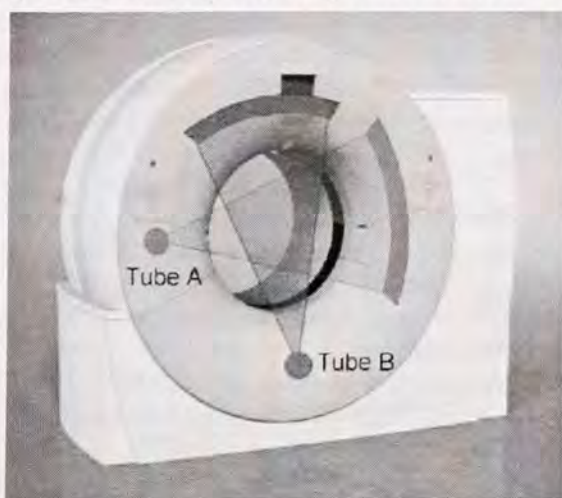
Configuration of Dual-Source CT scanner with two X-ray tube sources and two corresponding detectors offset by 90°.²⁴
